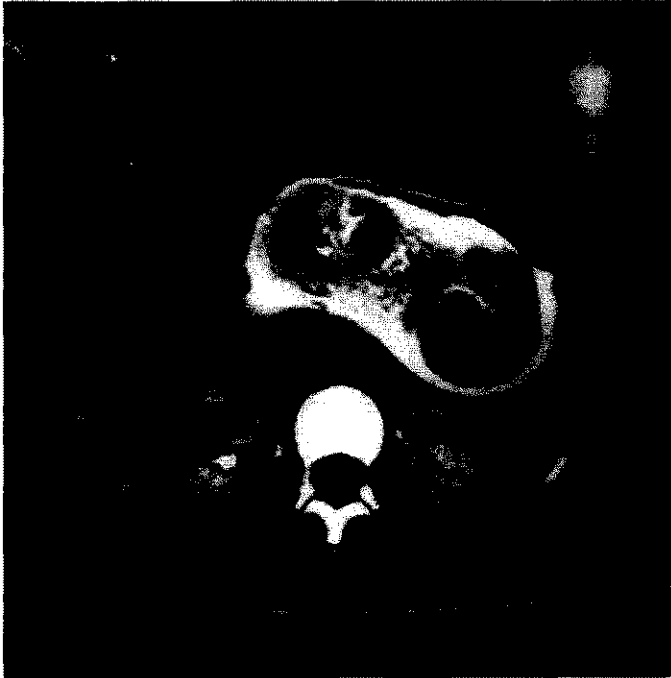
CT scan showing stomach almost filled with trichobezoar
